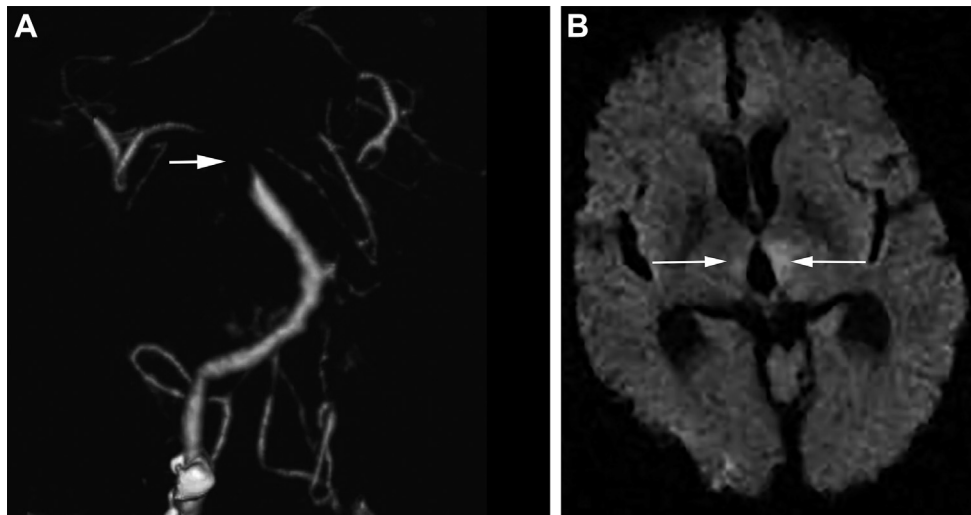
(A) The preoperative, 3-dimensional computed tomography angiography shows an occlusion (arrow) of the upper basilar artery trunk. (B) The preoperative diffusion-weighted imaging (axial) shows a small affected area (arrows) in the left posterior thalamus.
